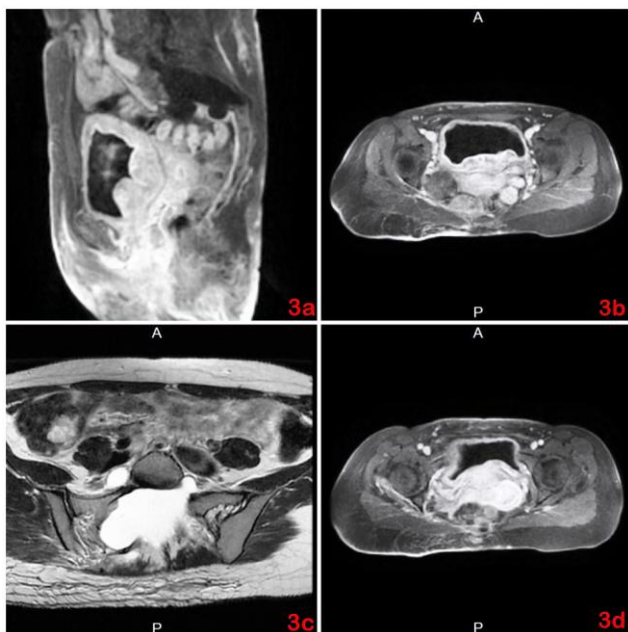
A), B) MRI images showing irregularly thickened walls and uneven internal contours of the bladder wall in the area of the trigonum and the two urethral ostia; C), D) Deformation of the anterior sacral wall with bilateral meningoceles at the Ec1 and Ec2 levels and diffuse engagement of the posterior wall of the bladder in its entire volume
